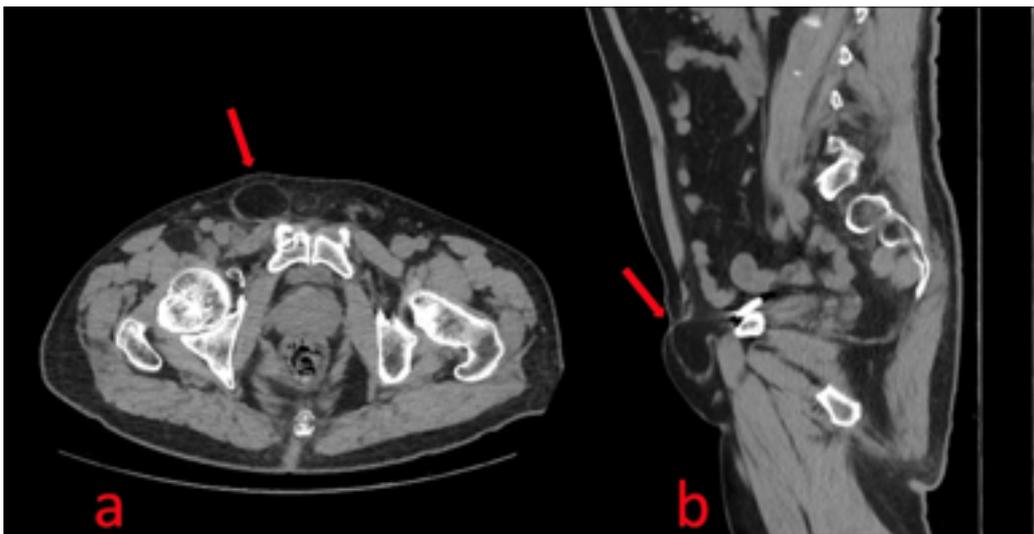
CT Image of non-incarcerated incisional hernia sac due to previous surgery. No abdominal organ in sac because of spontaneous reduction by lay position during CT scan. a) Transvers view. b) Sagittal view.
